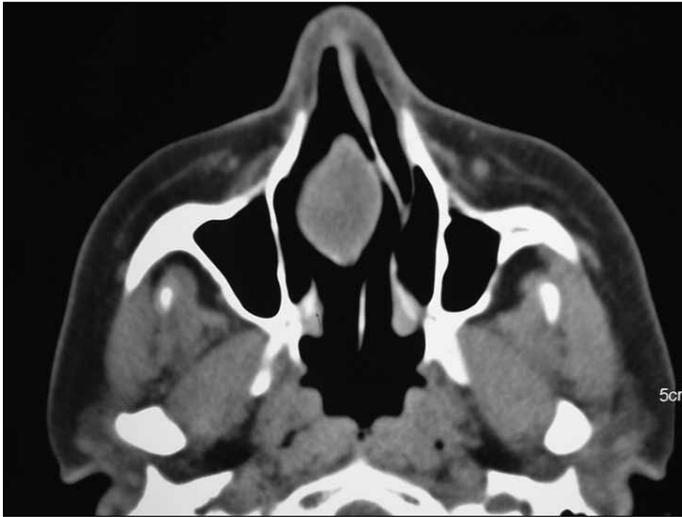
Axial CT scan of patient 1 shows a hypointense soft tissue filling the middle turbinate and shifting the septum
